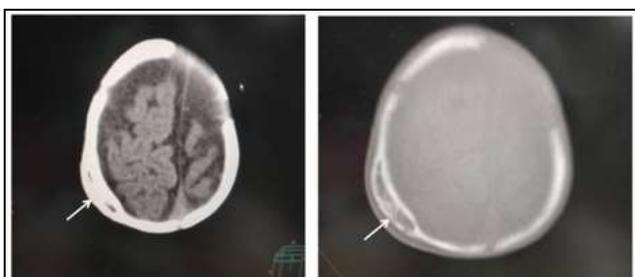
Plain CT Brain Axial Sections in Brain and Bone Window Show Calcified Subperiosteal Hematoma in Right Parietal Bone (White Arrow) - Calcified Cephalhaematoma
